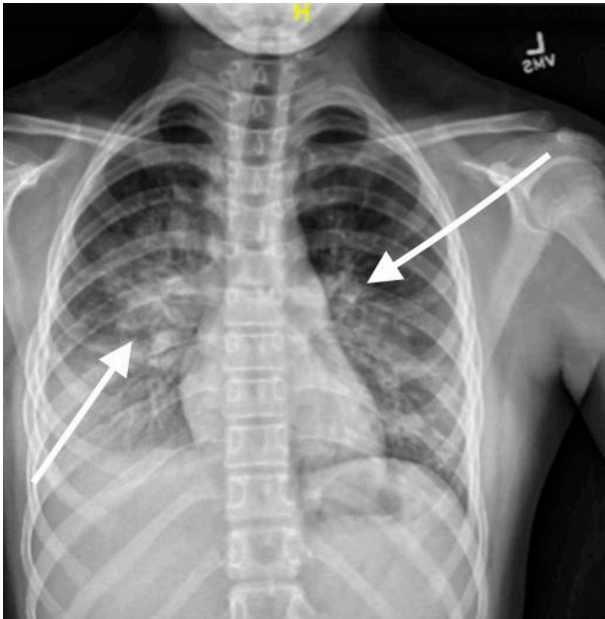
Chest X-ray, anteroposterior (AP) view on third presentation to emergency department showing signs of pneumonia with consolidation.
